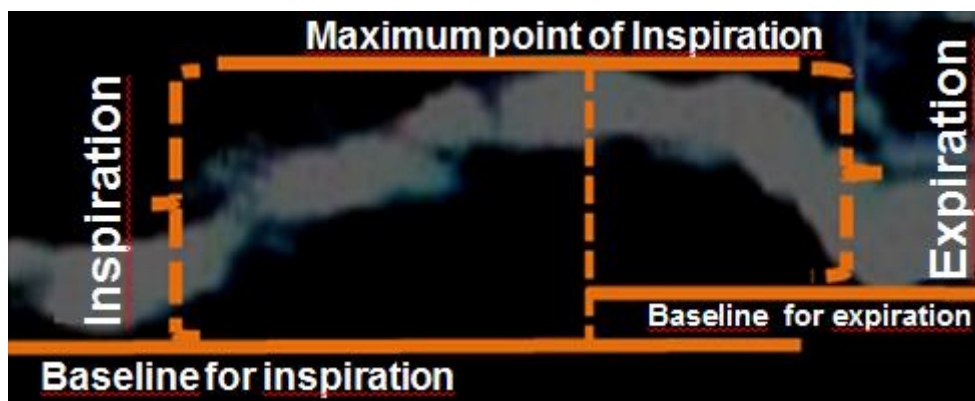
Example of diaphragm excursion seen on mode M ultrasound.
